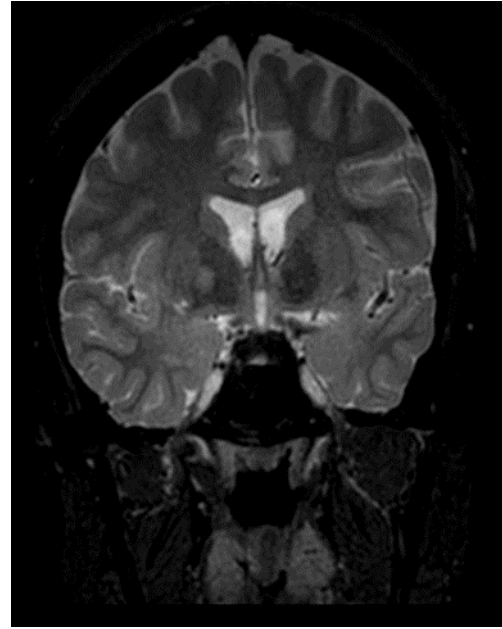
High field MRI, T2WI, coronal section, hypointense lesion at the level of the right basal ganglia with central hyperintensity
